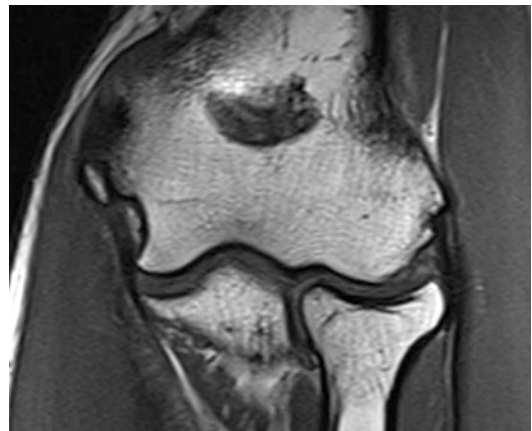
Magnetic resonance imaging appearance of the long-term effects of medial epicondyle apophysitis in an adult baseball pitcher
